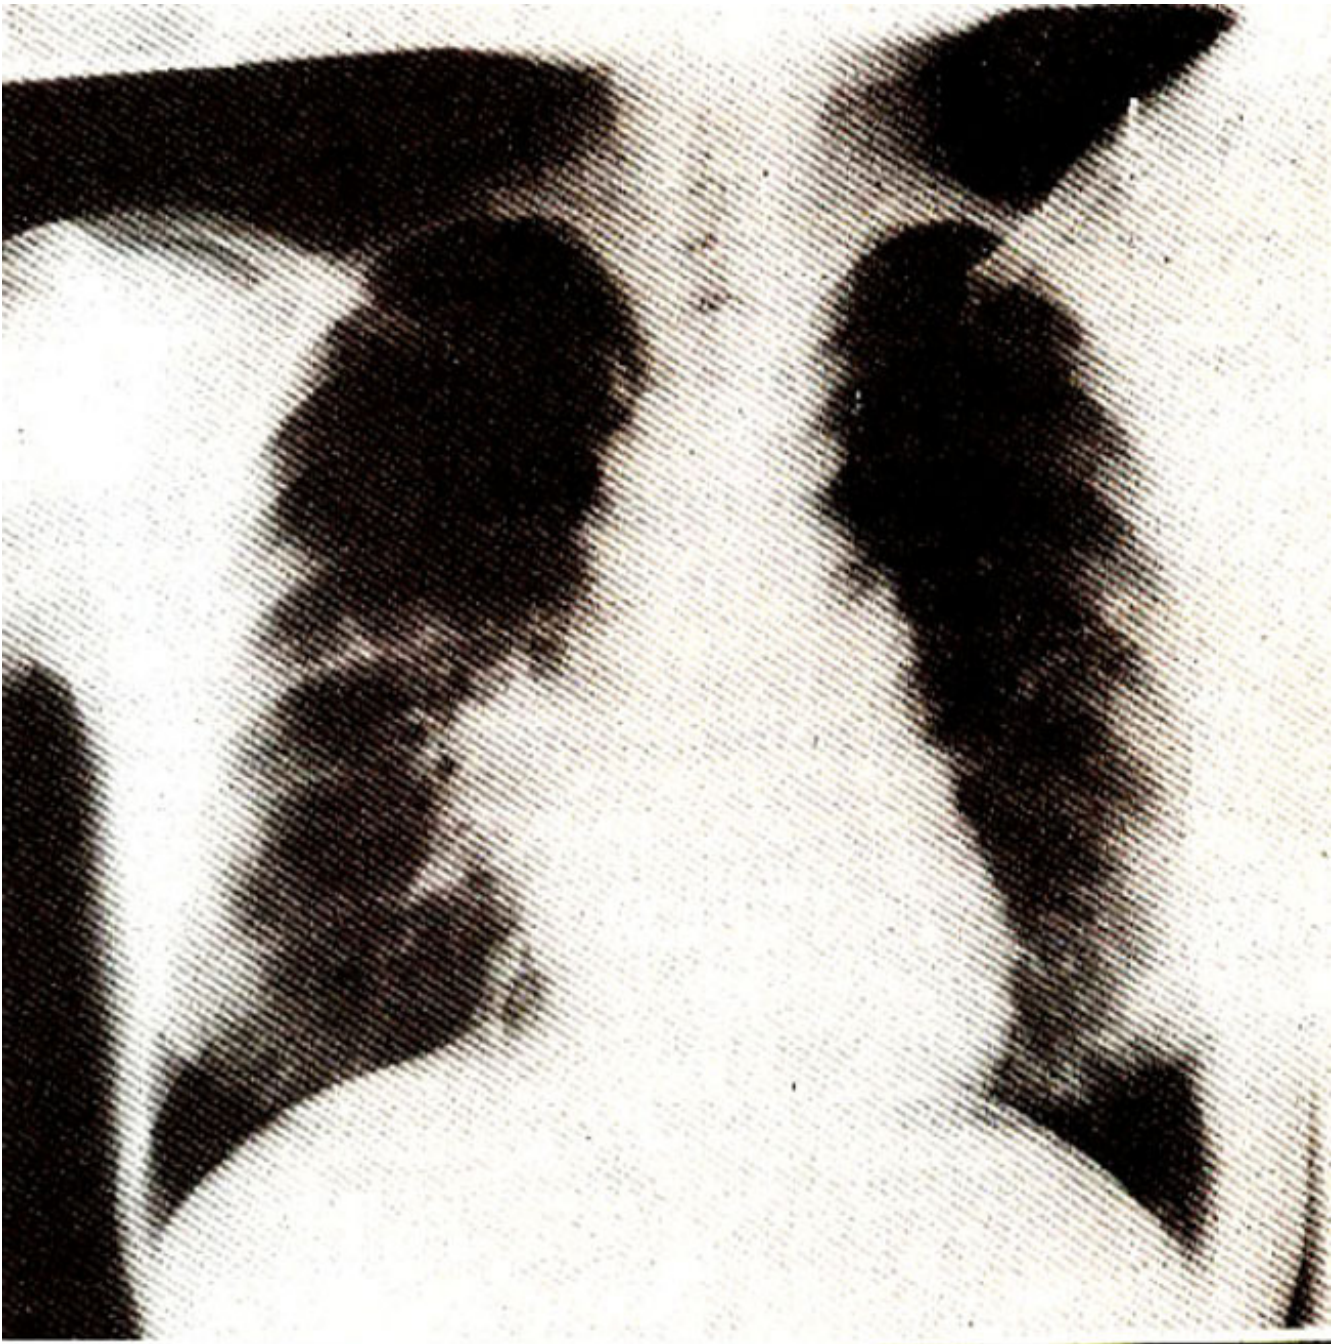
Chest X-ray after 3 months showing significant improvement
